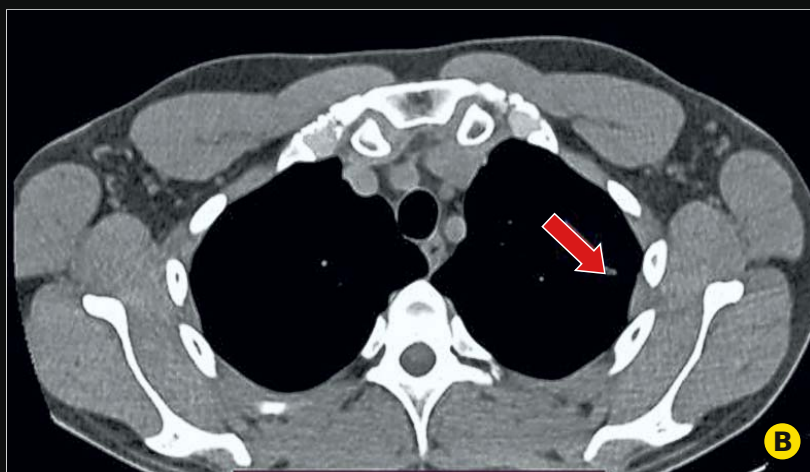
PET CT Scan - nodular lesion in the apico-posterior segment of the LUL, exhibiting slightly increased metabolic activity, small areas of consolidation, ground glass appearance and an uncertain substrate.
